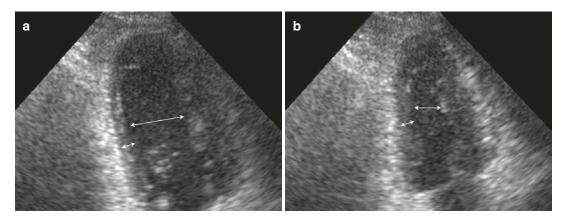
A case of inferior wall infarction. Apical 2 chamber view showing lack of wall thickening from diastole (a) to systole (b)
